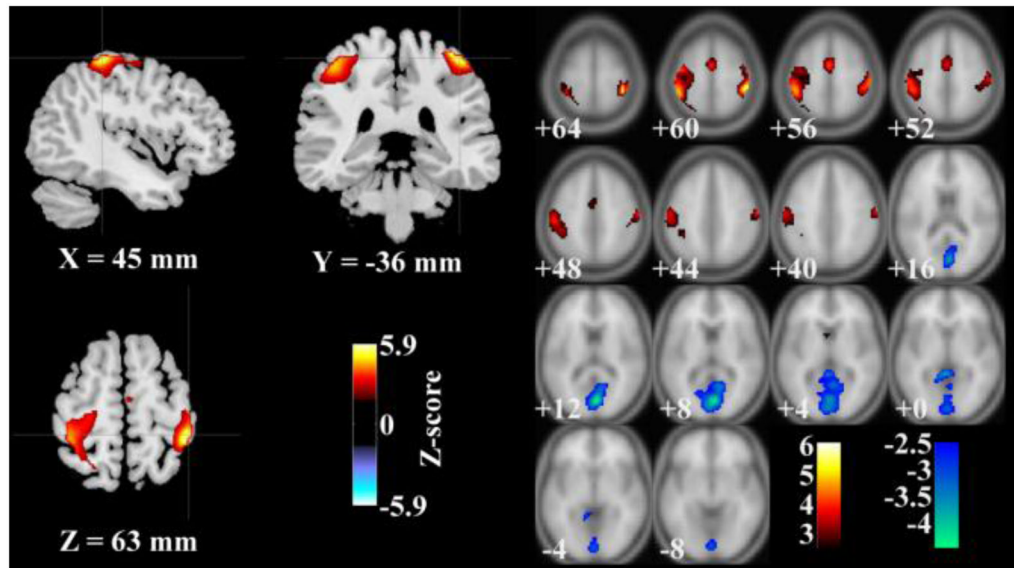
Map of brain network for the identified functional magnetic resonance imaging component ($|Z| > 2.5$): left: regional view; right: slice view.
